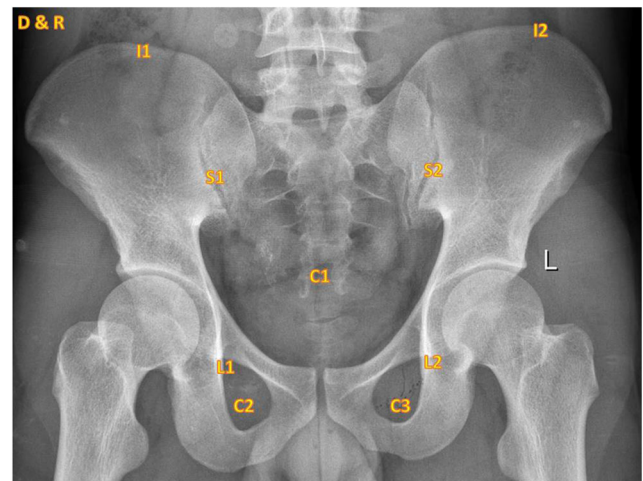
Interpretation of X-ray pelvis. C1: pelvic ring; C2 and C3: obturator rings; L1 and L2: Shenton's line; S1 and S2: sacro-iliac joints; I1 and I2: iliac crest
